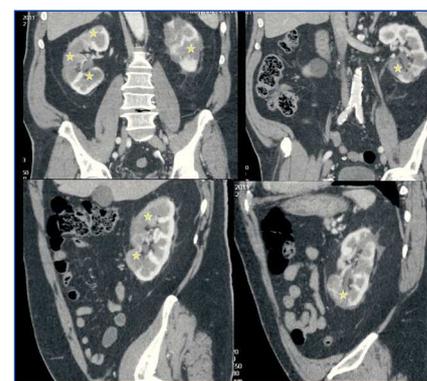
Abdominal axial computed tomography.
